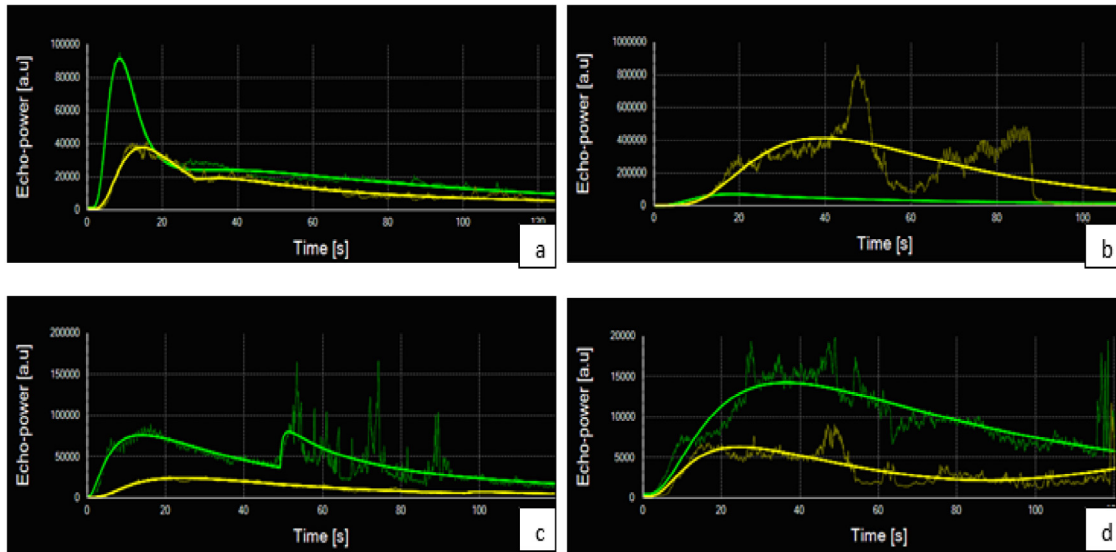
Time–intensity curves of normal uterine tissue for all four patients. (a) Patient 1. (b) Patient 2. (c) Patient 3. (d) Patient 4. Colors correspond to the selected regions of interest on the contrast-enhanced ultrasound image: *green* = myometrium, *yellow* = endometrium.
